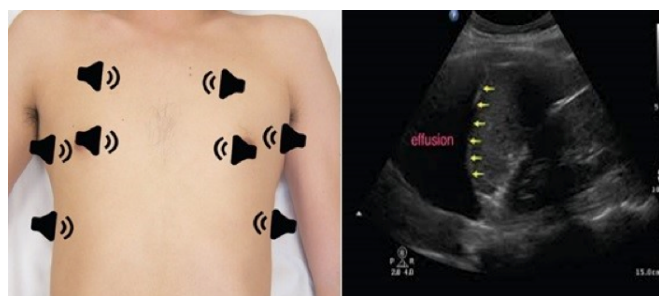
Thorax ultrasonography showing pleural effusion.
